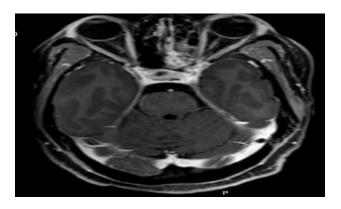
Pre-operative MRI T1-weighted image with contrast (Gd) showing a hypersignal left sphenoid sinusitis with extension to the anterior cavernous sinus and left orbital apex.
